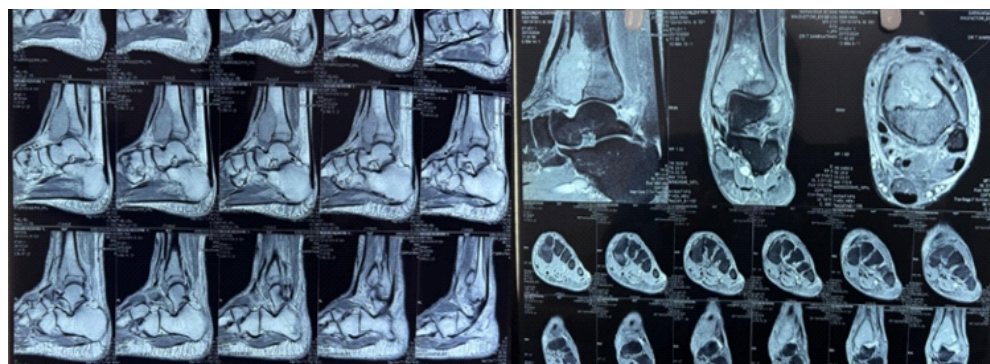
Different cuts in magnetic resonance imaging ankle.
